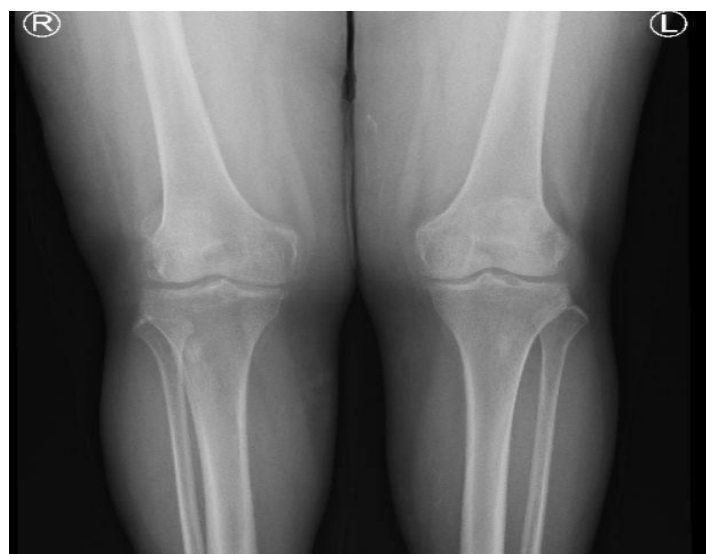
Pre-operative x-ray of both knees showing KL grade IV osteoarthritis
